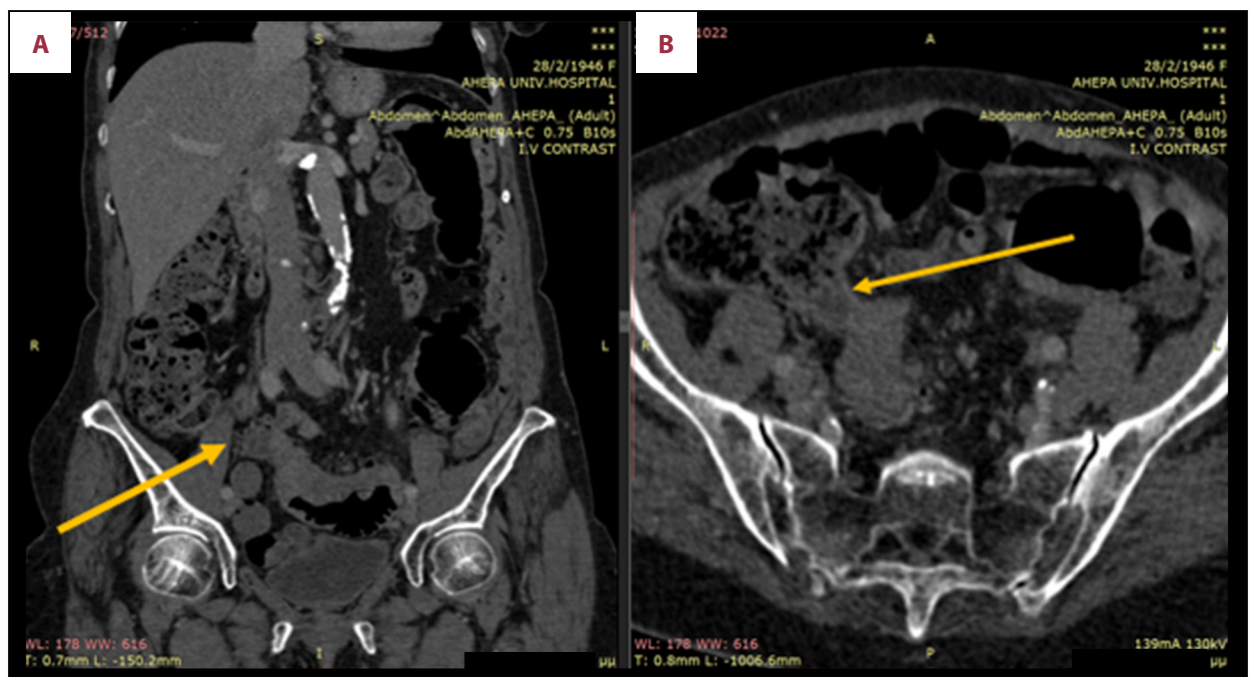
Computed tomography scan at admission (A, B), detection of the fistulous tract (arrows) between the sigmoid colon and the cecum.
